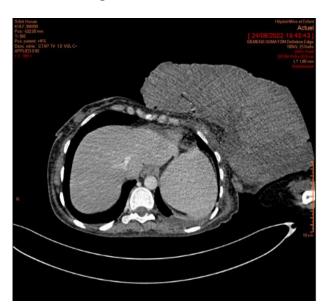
CT scan with low-abundance pleural effusion
